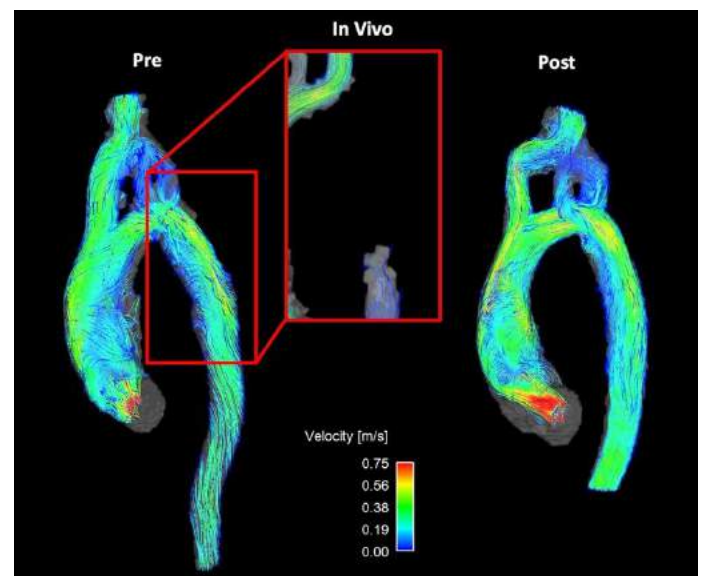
Comparison of pre- (left) and post-repair (right) in vitro model flow fields derived from 4D flow MRI for patient 2. High velocity COA jet observed in pre-repair case is relieved with repair.
